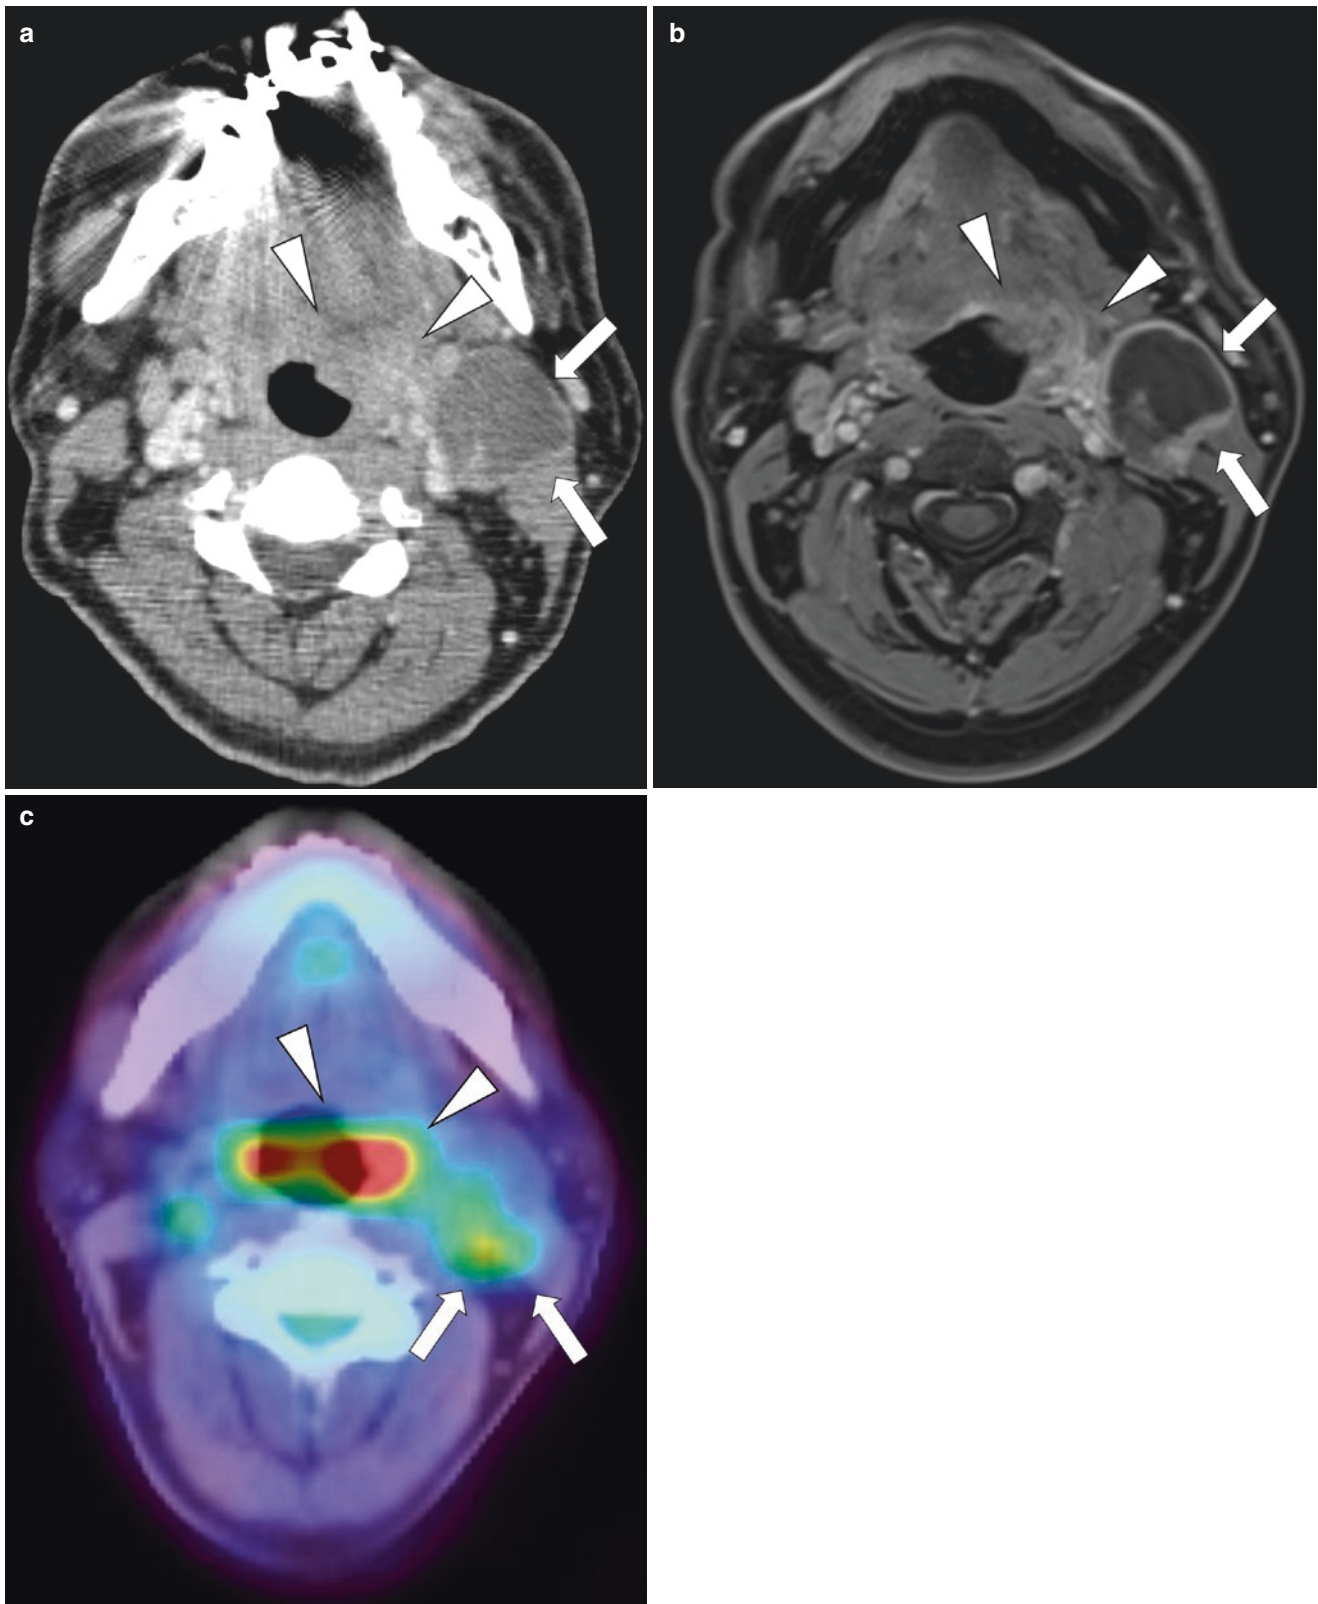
A 49-year-old man with HPV-associated oropharyngeal carcinoma (a, b, and c, *arrowheads*). Contrast-enhanced CT and contrast-enhanced MR presented the necrotic lymph node metastasis on
